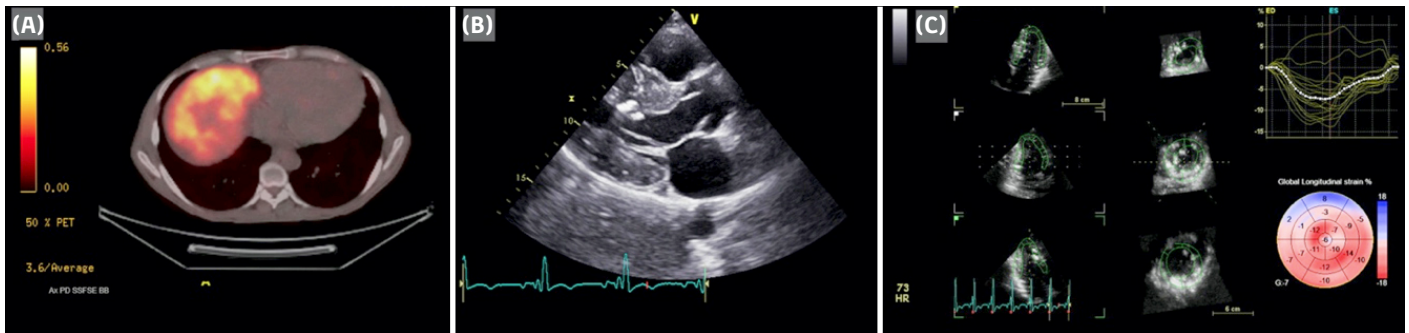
Post-treatment anatomic and metabolic response of cardiac metastases. (A) Follow-up axial fused fluorodeoxyglucose positron emission tomography (FDG-PET) image demonstrating marked reduction in myocardial FDG uptake, consistent with significant metabolic regression. (B) Follow-up parasternal long-axis transthoracic echocardiography showing persistence of intramyocardial hyperechoic masses despite therapy. (C) Follow-up speckle-tracking echocardiography with bull's-eye representation demonstrating persistently reduced global longitudinal strain (-7.0%), indicating ongoing mechanical dysfunction.
